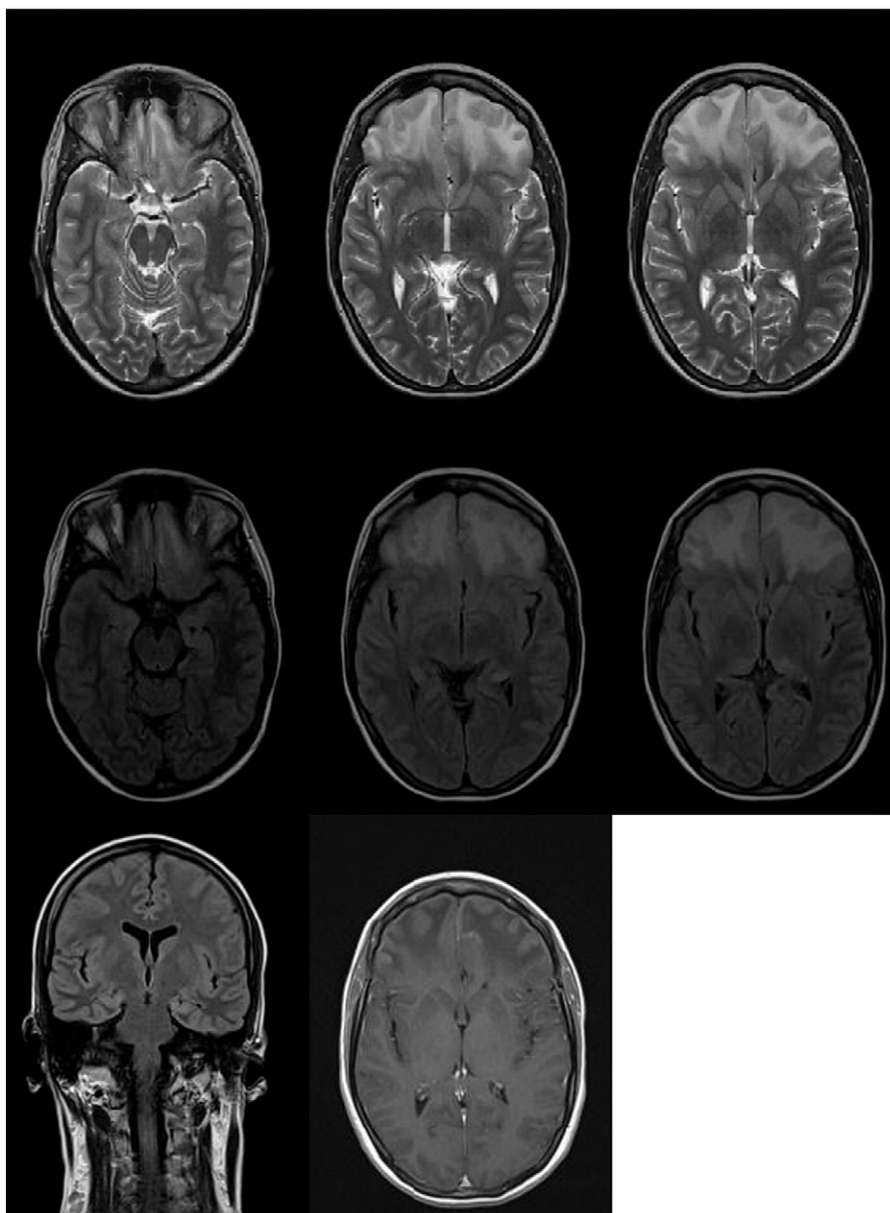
T2 and FLAIR images show hyperintense lesions in bilateral frontal lobes and thalamic and mesiotemporal regions (better seen on coronal FLAIR images). T1-weighted images show no contrast enhancement after gadolinium injection.
